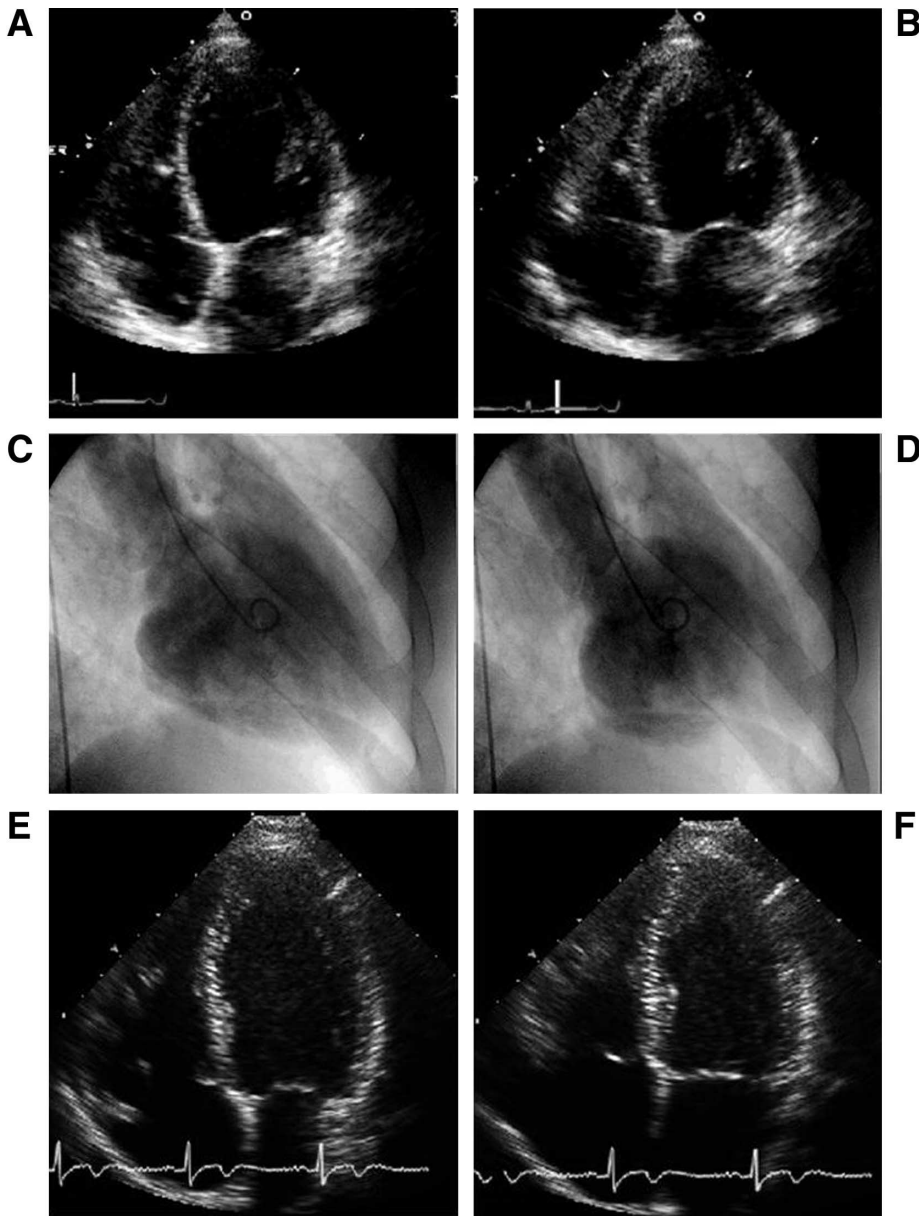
In the acute phase, an apical 4-chamber view shows akinesis of the basal and midventricular segments, with preserved contractility of the apical segments during diastole (A) and systole (B). End-diastolic (C) and end-systolic (D) ventriculograms of the case show akinesia of the basal and middle segments of the left ventricle and normal contractility of the apical segments. On day 18 after surgery, the apical 4-chamber view shows normalized ejection fraction and wall motion during diastole (E) and systole (F).
